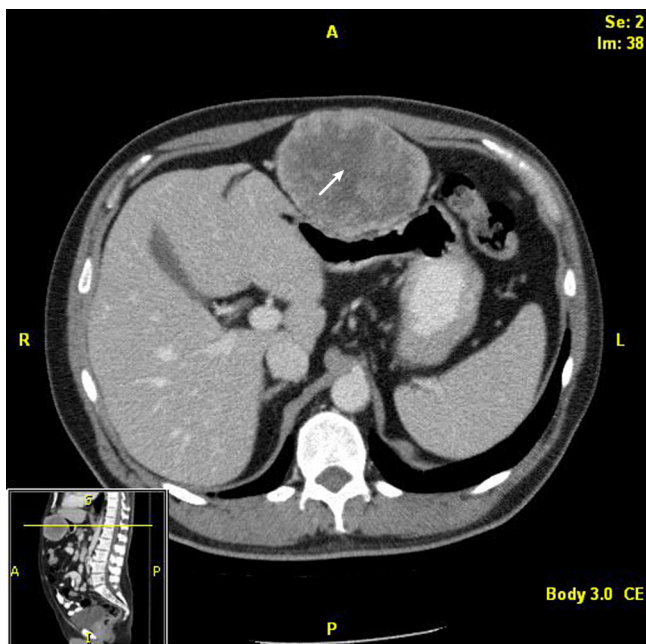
Computed tomographic scan showing large metastasis in the falciform ligament. The arrow indicates the metastasis.
